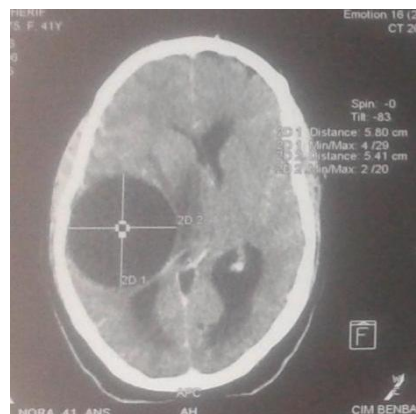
Pre surgical cerebral CT axial section of a right temporo-parietal hydatid cyst.
